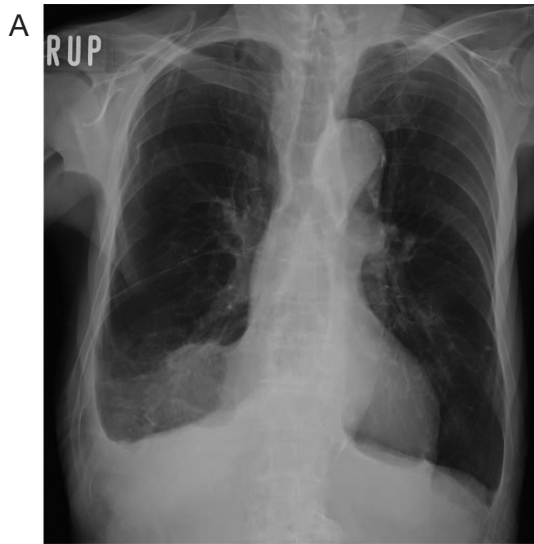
Chest radiograph (A) and computed tomography (CT) scan (B) upon admission. The chest radiograph shows a consolidation in the lower field of the right lung (A), and the CT image reveals a 5-cm diameter mass with areas of low attenuation inside (B). Pleural effusion and atelectasis in the lower lobe of the right lung appeared on day 7 (C).
